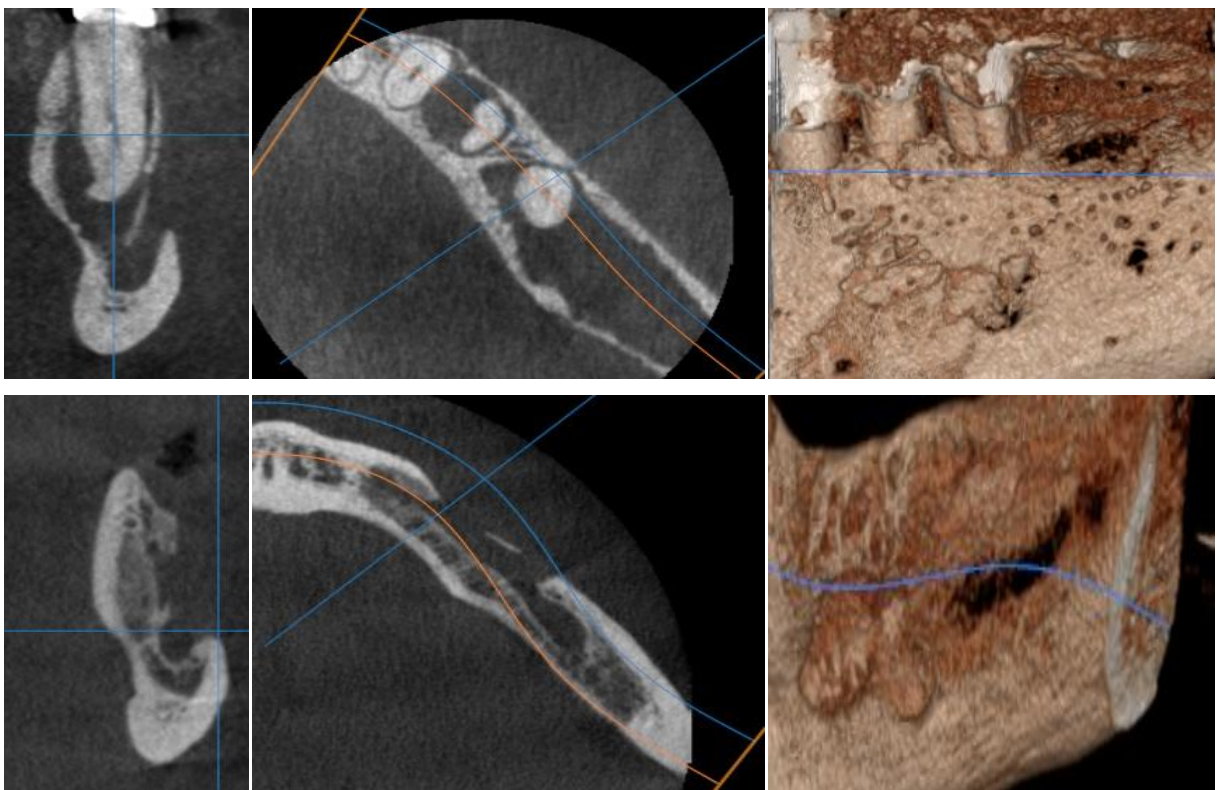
The multiplanar and 3D CBCT- scans in a preoperative case of left antero-lateral mandibular region inflammatory radicular cysts and the same examination done 12 months after surgical removal with bone repair revealed
